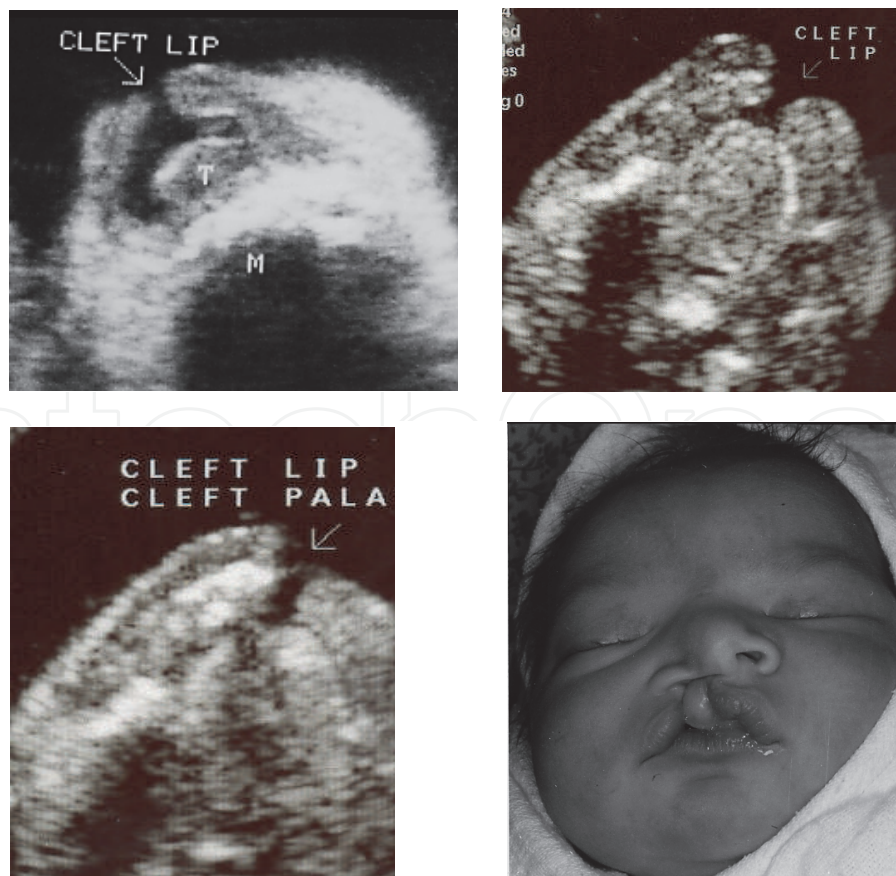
Sonographic pictures of cleft lip
